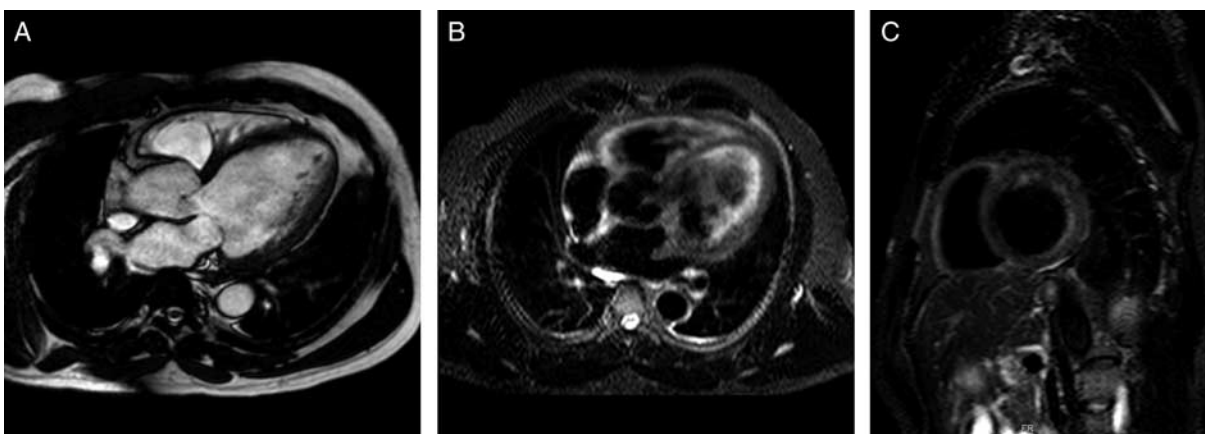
A, CMRI 5-chamber view, SSFP sequence in a patient with DCM. No signs of edema on the T2-weighted axial 5-chamber (B) and short-axis views (C).
